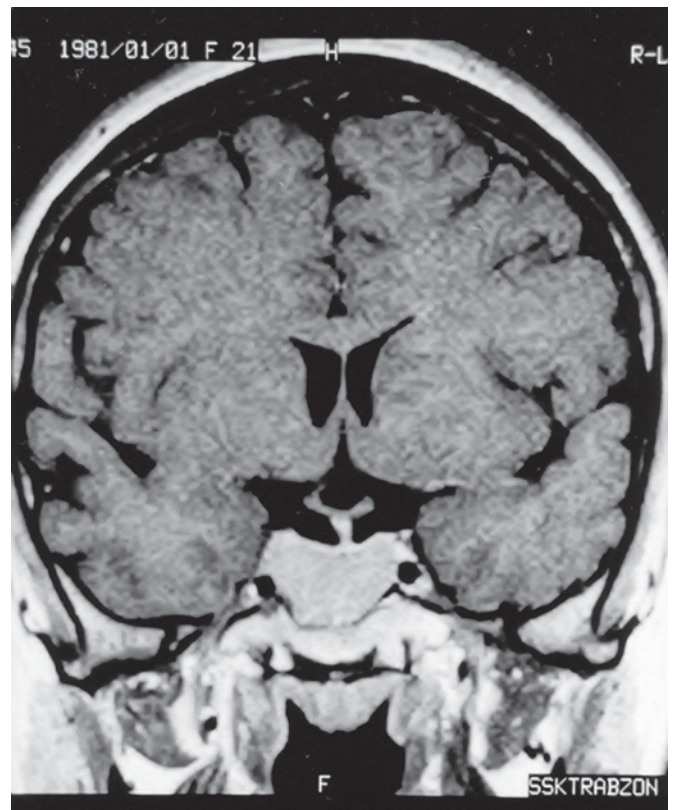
Contrast enhanced T1-weighted coronal MRI scan of TSH-secreting pituitary adenoma before treatment with octreotide-LAR. MRI shows a macroadenoma of the pituitary gland before treatment.
